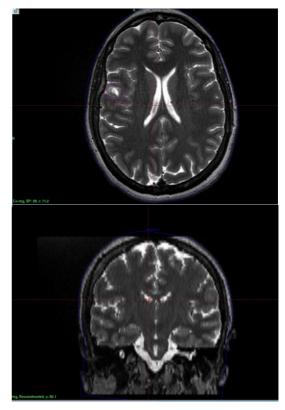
Follow up T2 -weighted MRI images obtained after 12 months of GKRS shows the same delineation but hyperintense T2 signal within target delineation of treatment is much reduced (partial remission).
